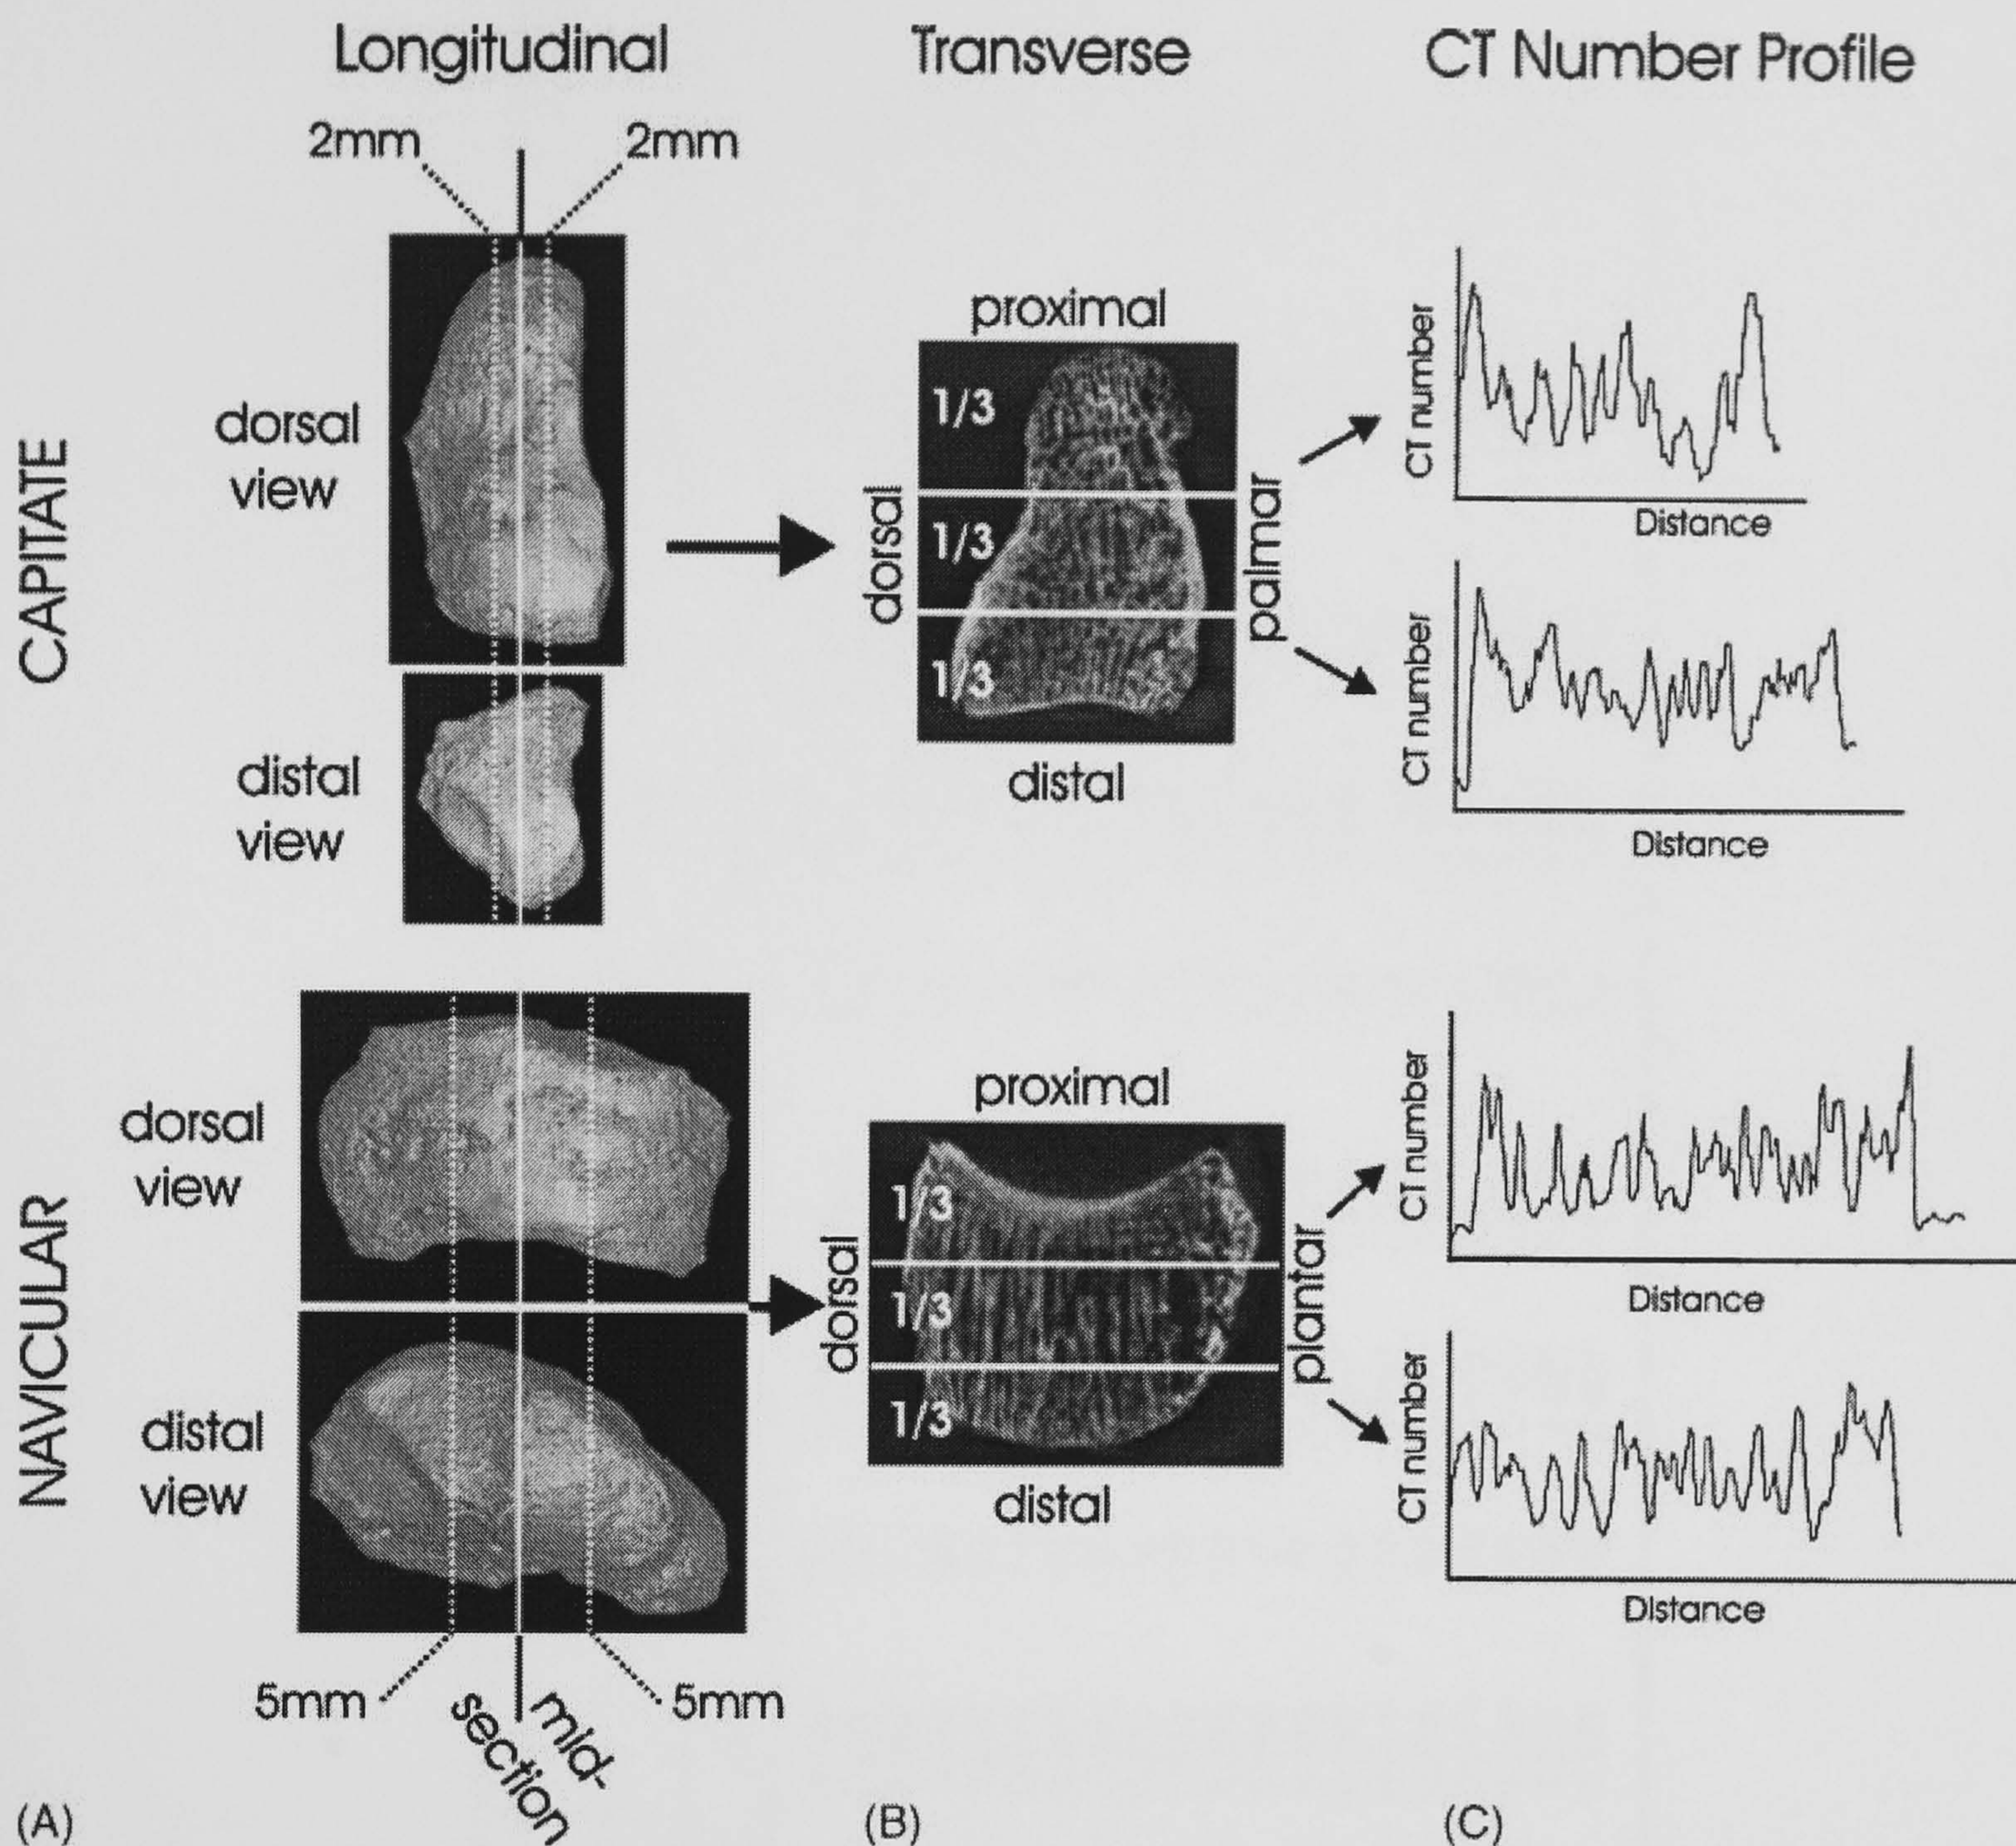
Planes of sections through the images of the capitata and navicular, reconstructed from μ CT images, are shown. (A) depicts the three virtual longitudinal cuts; bones are scaled to approximately the same size to indicate the relative positions of the planes. (B) shows how each of the slices is cut in the transverse plane for calculation of trabecular thickness using the HMH-method. (C) displays examples of CT number profiles. Images in (B) and (C) are not to scale.
